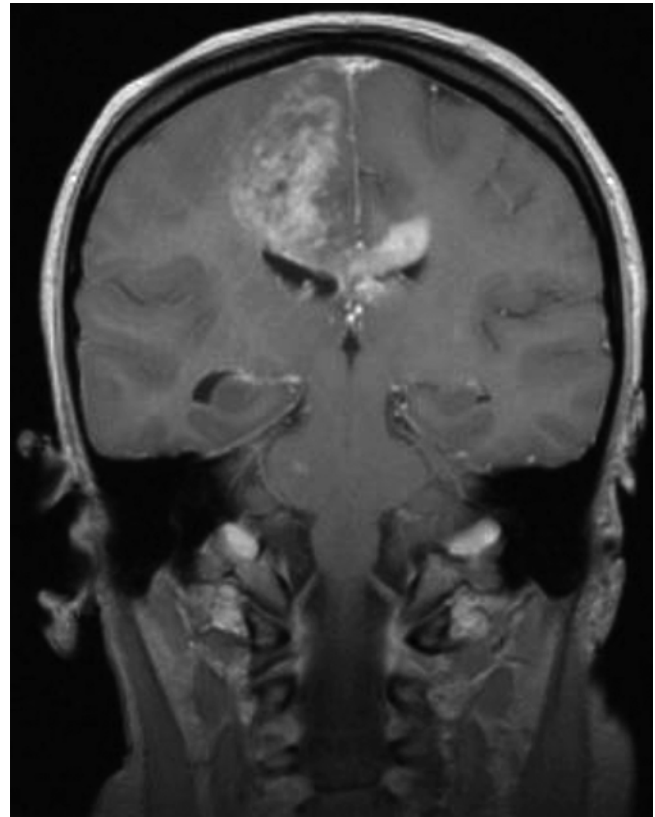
Magnetic resonance image of supratentorial glioblastoma multiforme (Courtesy of Amar Gajjar)
